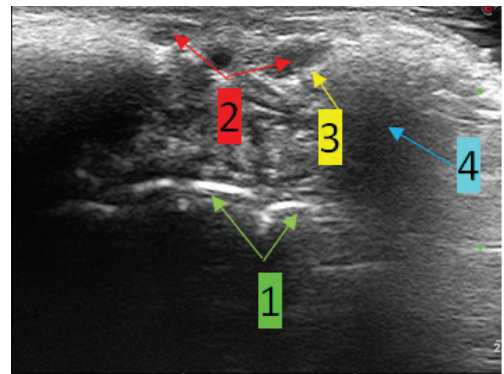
Sonogram of the lips, sagittal plane (arrow 1 – teeth). The hypoechoic silicone filler boluses (arrow 2 – hypoechoic boluses), which was injected 8 years ago, oval shaped, with clear and even contours, with the fibrous capsule (arrow 3 – fibrous capsule) without a perifocal edema of the upper and lower lip soft tissues was visualized. The visualization of the upper and lower lip tissues had an atypical structure, visualization of the orbicularis oris muscle was hindered. There was also a posterior acoustic shadowing artifact caused by the superficial hyperechoic structures (arrow 4 – posterior acoustic shadowing artifact). Echo signs of fibrotic changes of the lips with encapsulated silicone filler fragments
